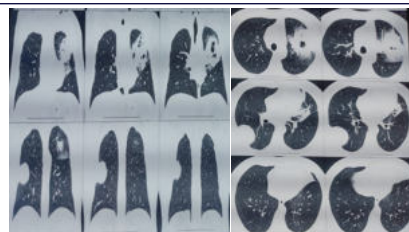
CT scan of thorax images solidly looking soft tissue space occupying lesion on right lung field and cavities within dense consolidations of left upper lobe.
